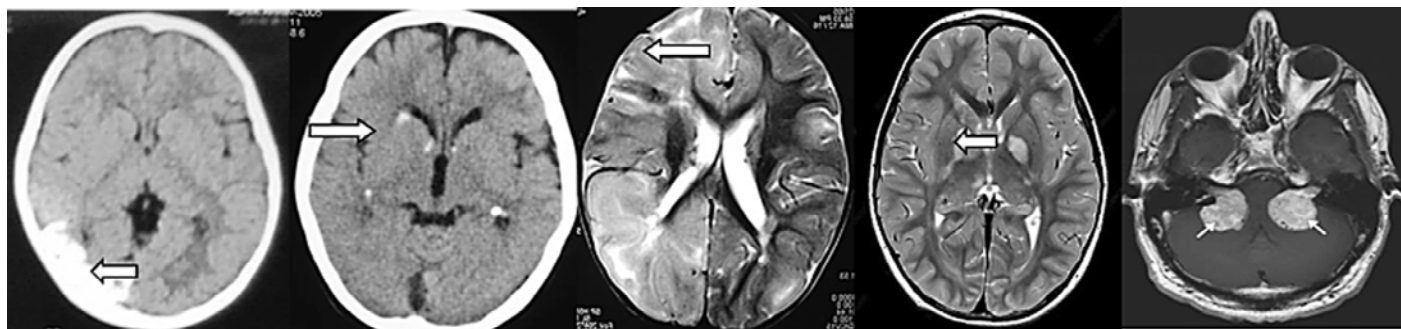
Plain CT shows calcified pial angioma in right parieto occipital region suggestive of Sturge Weber Syndrome
